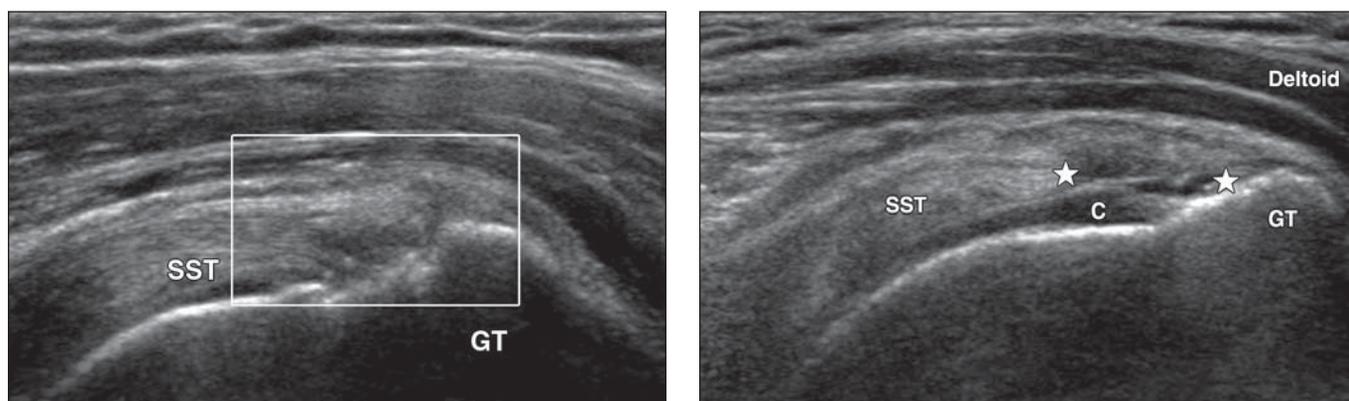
59-year-old man with asymptomatic partial-thickness tear of bursal surface of supraspinatus tendon. Long-axis ultrasound image of supraspinatus tendon shows predominately hypoechoic bursal surface tear (box). Articular fibers deep to bursal surface tear are intact. SST = supraspinatus tendon, GT = greater tuberosity.
